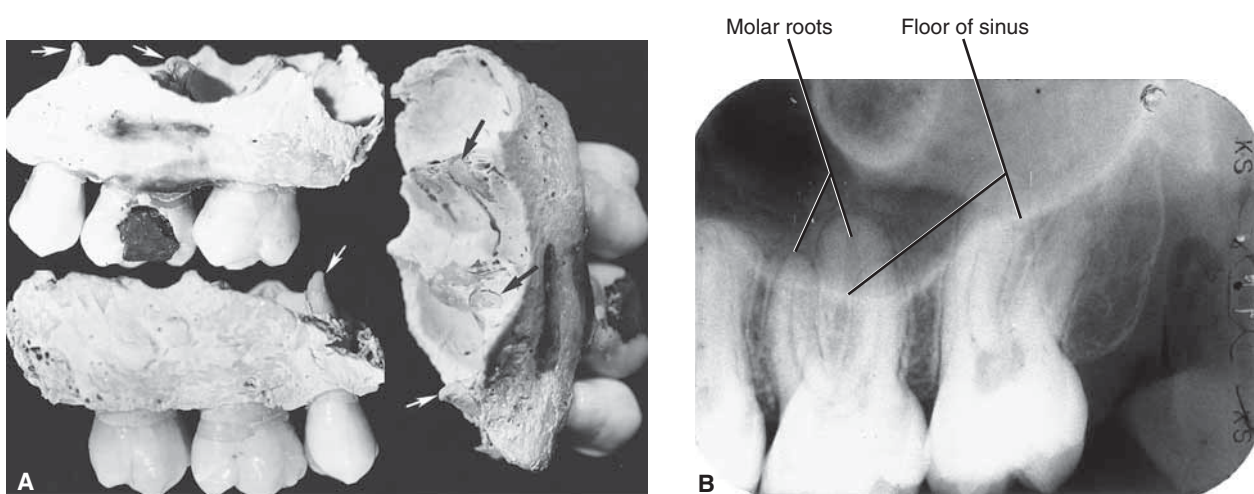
A. Three views of part of the left alveolar process of the maxilla surrounding the roots of the maxillary first and second molar and second premolar. Note the root tips (apices) shown by *arrows* extending out of the maxilla into what would have been the floor of the maxillary sinus space in an intact skull. B. Radiograph of the maxillary molar region showing the roots of the first molar several millimeters deep into the maxillary sinus (dark area surrounded by white border). Parts of the roots of the second molar are also within the sinus cavity. The root tip of the second premolar root is in the sinus as well. This is a common relationship.
